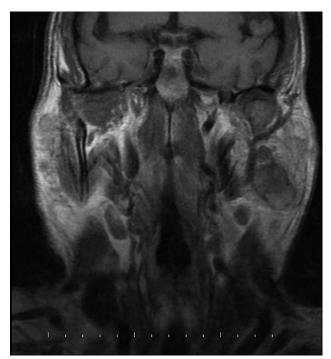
MRI coronal plane image of the parotis before contrast injection.
